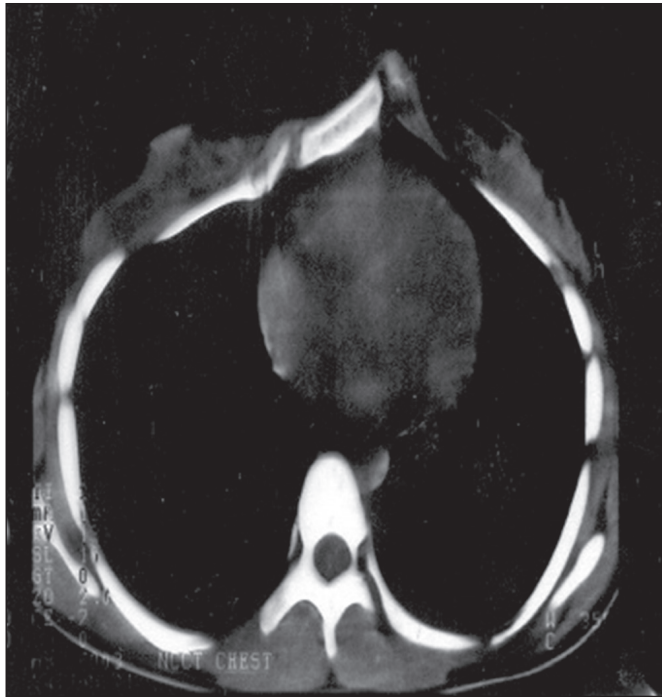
A plain CT scan of the chest confirmed the lateral variety of pectus carinatum.
